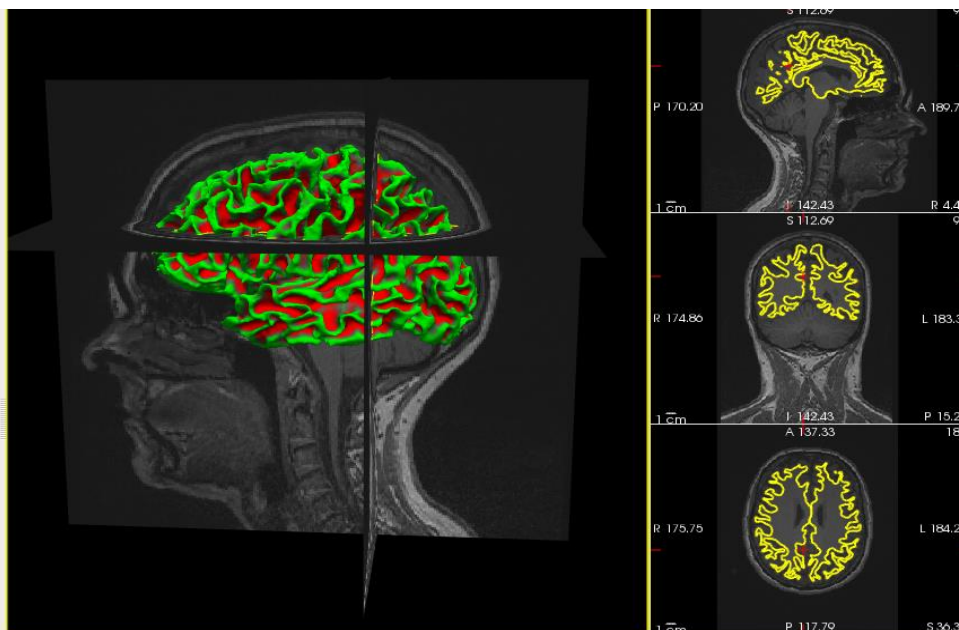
T1-weighted image with WM surface model. Software used is FreeSurfer.
